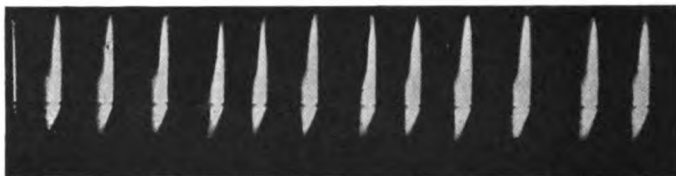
Discharge through x-ray tube and Caldwell-Simon interrupter, 3-cm. spark equivalent.
